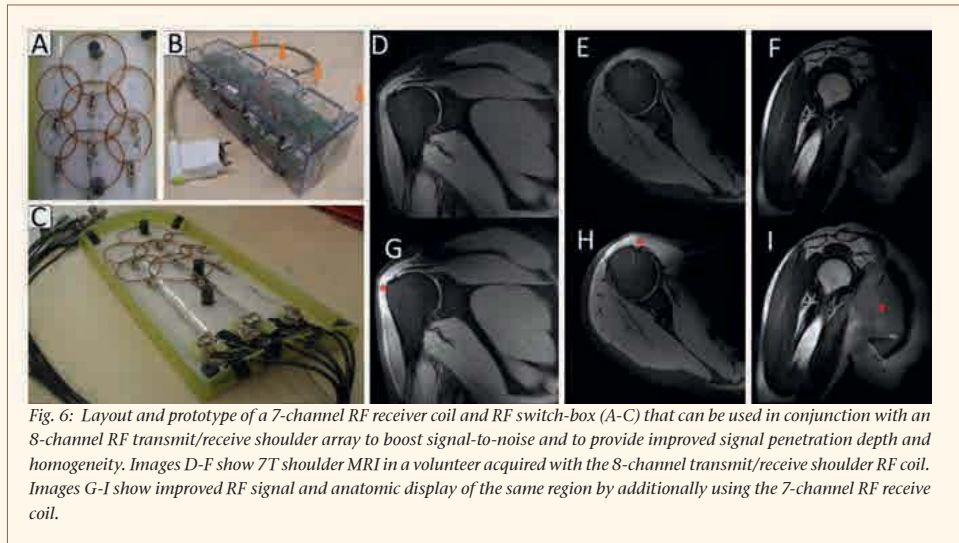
Layout and prototype of a 7-channel RF receiver coil and RF switch-box (A-C) that can be used in conjunction with an 8-channel RF transmit/receive shoulder array to boost signal-to-noise and to provide improved signal penetration depth and homogeneity. Images D-F show 7T shoulder MRI in a volunteer acquired with the 8-channel transmit/receive shoulder RF coil. Images G-I show improved RF signal and anatomic display of the same region by additionally using the 7-channel RF receive coil.
